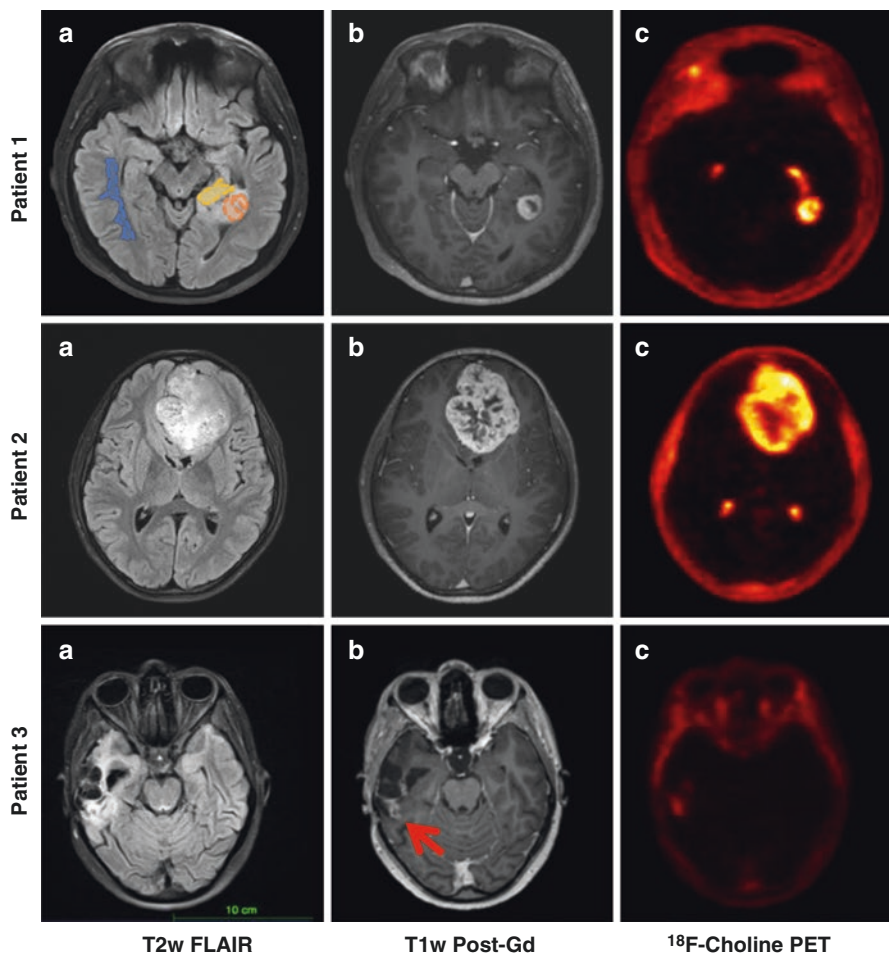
Axial T2w FLAIR (a), axial post-contrast T1WI (b) and axial ^{18}F Choline PET (c) in Patients 1–3
